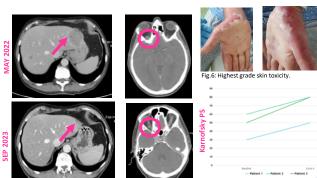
CT scan showing tumor burden reduction in the partial responding patient.
